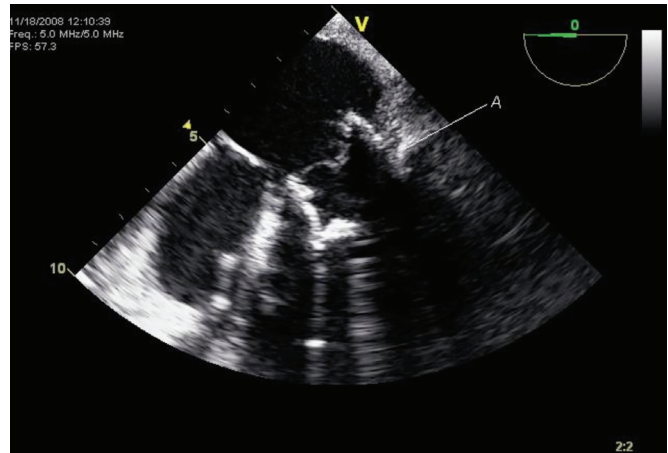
Postoperative transesophageal echocardiogram demonstrating the mitral bioprosthesis located in the atrium above the mitral annulus (A).
